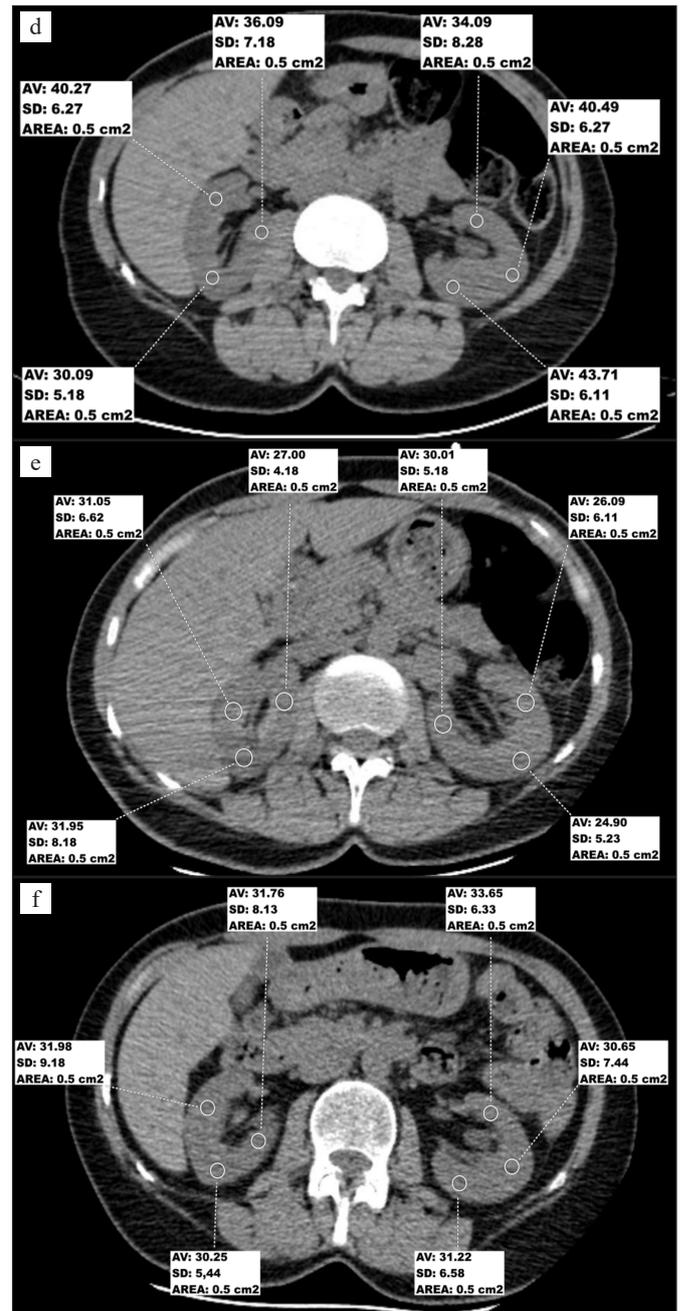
d-f. Renal parenchymal attenuation measurements are seen from slices passing through the kidney level on three consecutive axial plane non-contrast CT images [(a) mean RPA1=36.66 HU; (b) mean RPA 2=28.50 HU; (c) mean RPA 3=31.59 HU].
